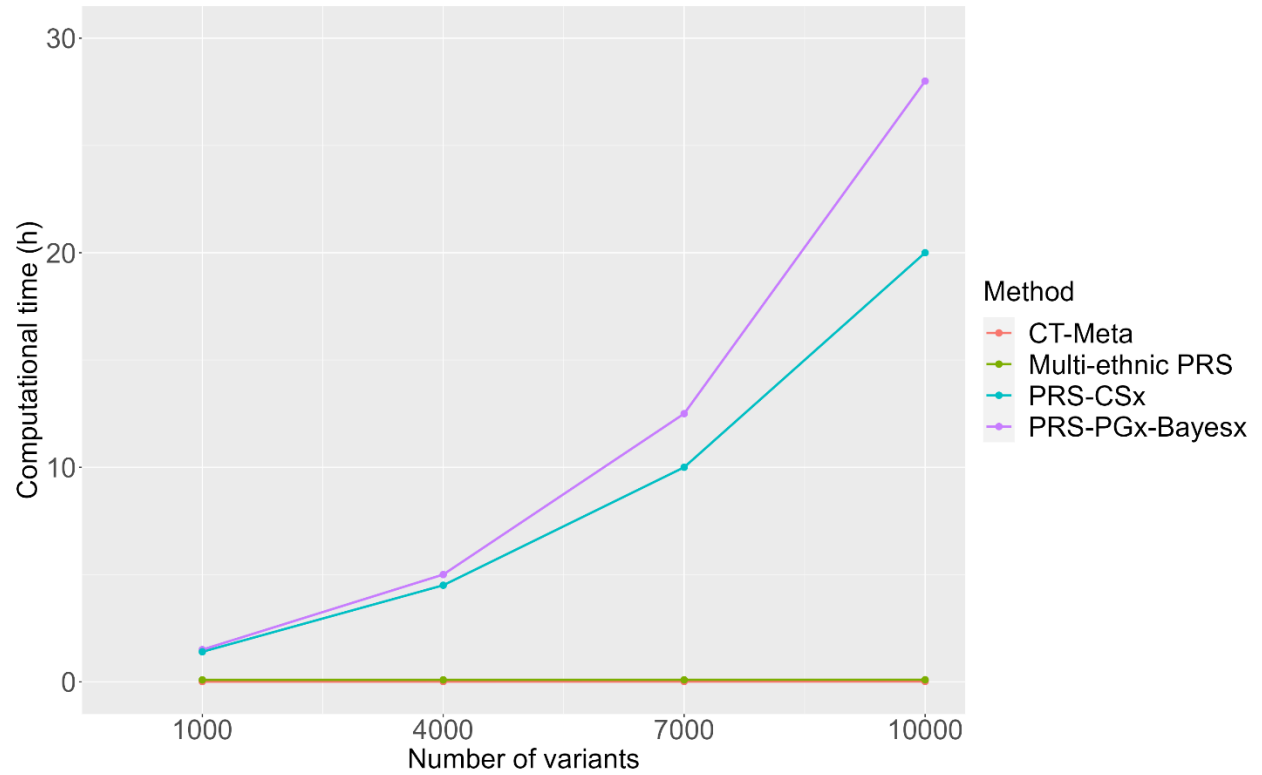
Computational time comparison between Bayesian based methods (PRS-PGx-Bayesx and PRS-CSx) and p-value thresholding based methods (CT-Meta and Multi-ethnic PRS). The computational time of PRS-PGx-Bayesx is based on 1,000 MCMC iterations. The number of variants = 1,000, 4,000, 7,000, and 10,000.
